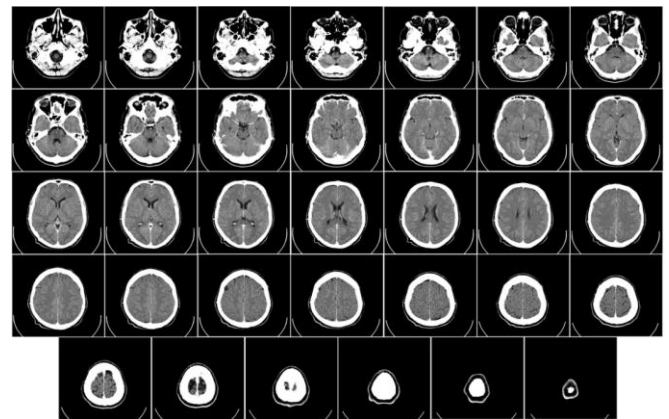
Computed Tomography of brain from skull to back taken with a contrast medium [22]
